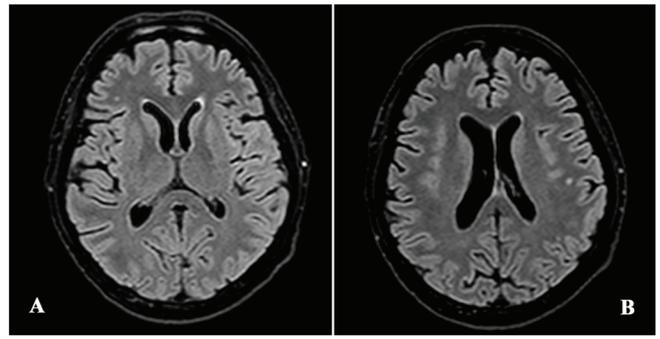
Magnetic resonance imaging of the patient performed on day 5 from admission, exhibiting subcortical dotted areas of altered hyperintense signal in (A) normal repetition time and (B) long repetition time sequences in the frontal lobe, which had a non-specific gliotic appearance.
